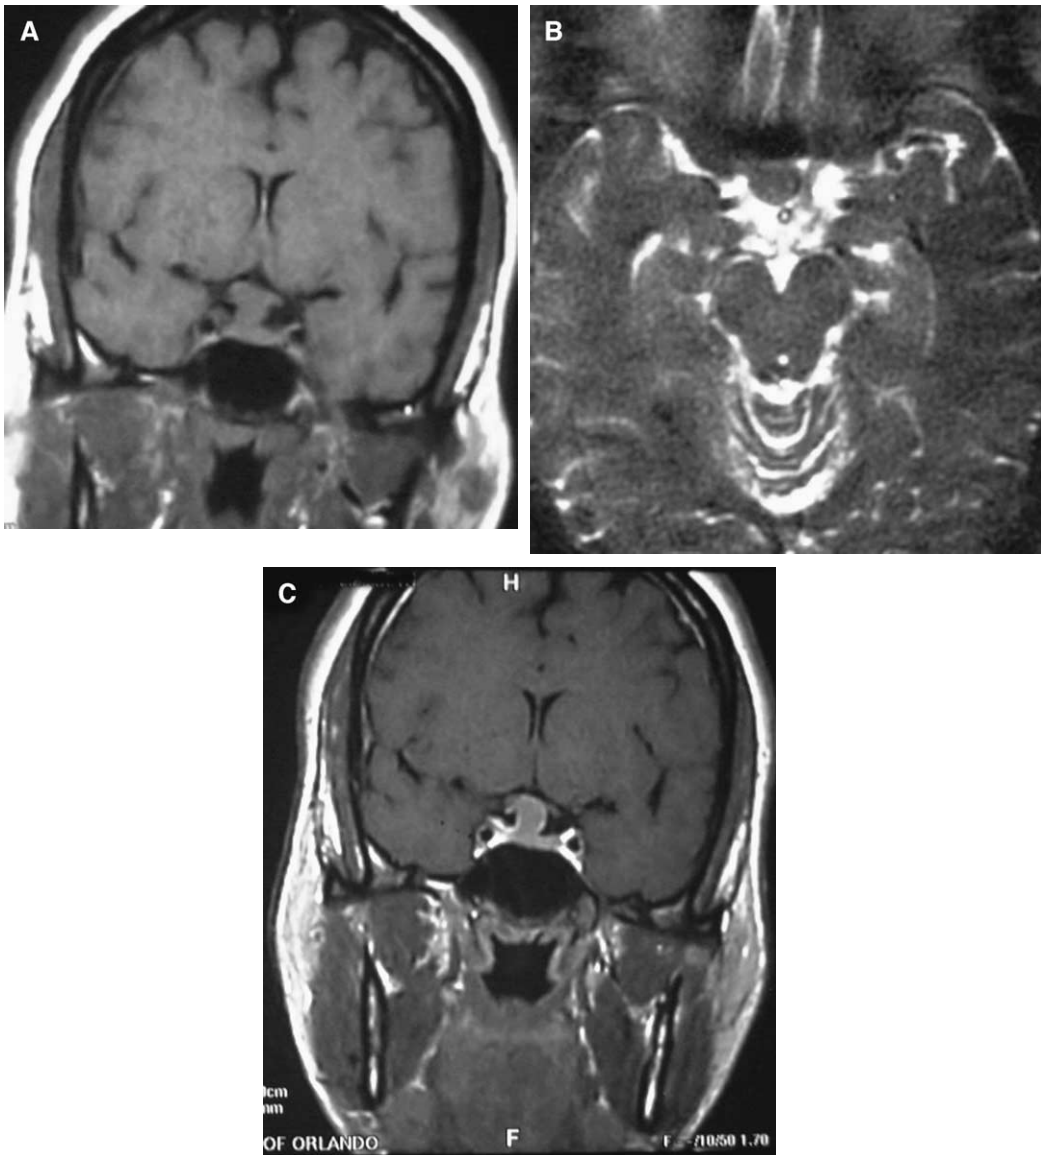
Small suprasellar meningioma. (A) Coronal T1-weighted image shows a small isointense suprasellar mass between the optic chiasm and pituitary gland. (B) Axial T2-weighted image shows the mass to be isointense to gray matter. (C) Coronal postcontrast T1-weighted image shows an enhancing mass in the suprasellar region with compression of the optic chiasm. Note that the mass has similar enhancement as the pituitary gland.
